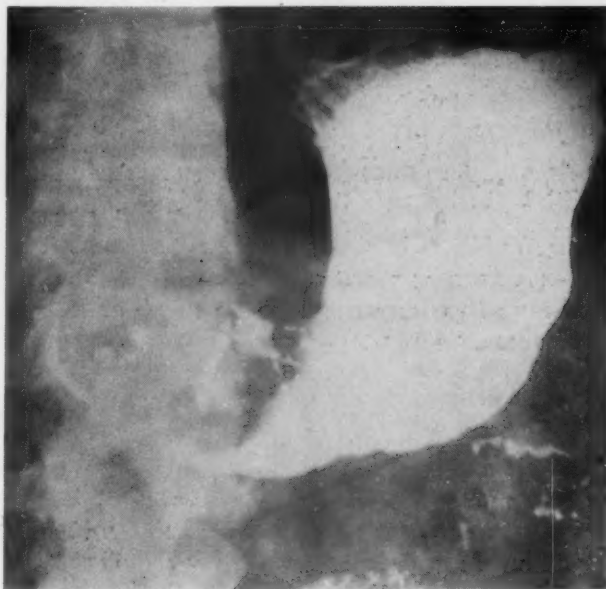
B.—Case 3, L. P.: Roentgenographic appearance of the neoplasm seen in Figure 11 A demonstrating a large intragastric mass in the pyloric antrum and flecks of barium in the ulcer craters.
